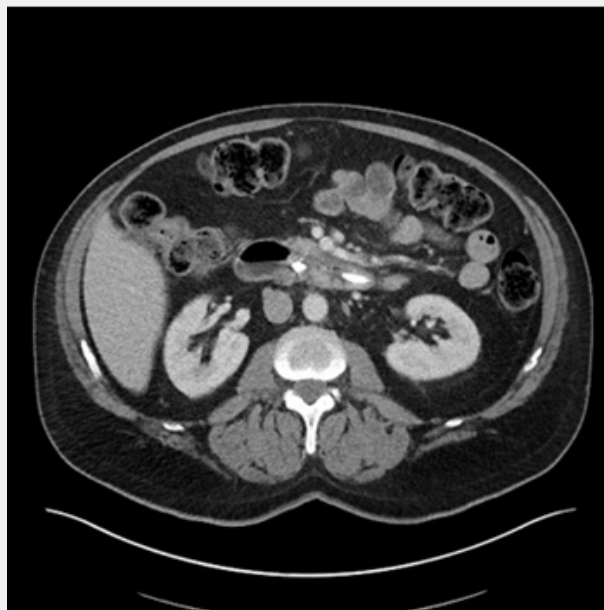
CT after using Pembrolizumab.
